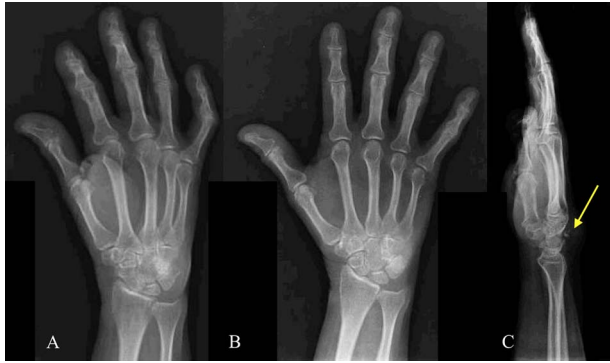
Right (A) oblique, (B) anteroposterior and (C) lateral hand X-rays with a triquetrum fracture (yellow arrow).
